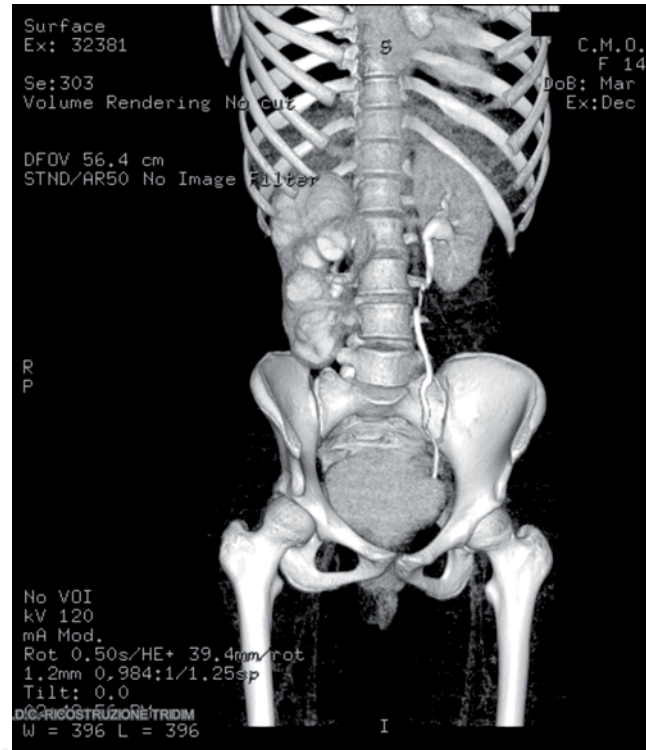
MRI, showing gross dilatation of all right renal calyces, faceting, an increase in the number of calyces, and a normal renal pelvis.
